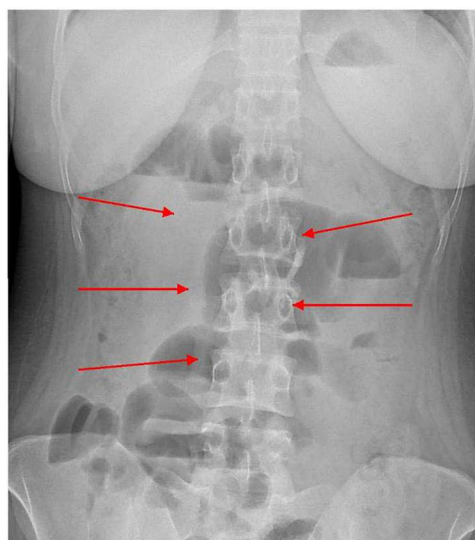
Plain abdominal radiograph demonstrating dilated central small-bowel loops with multiple air–fluid levels (arrows).
